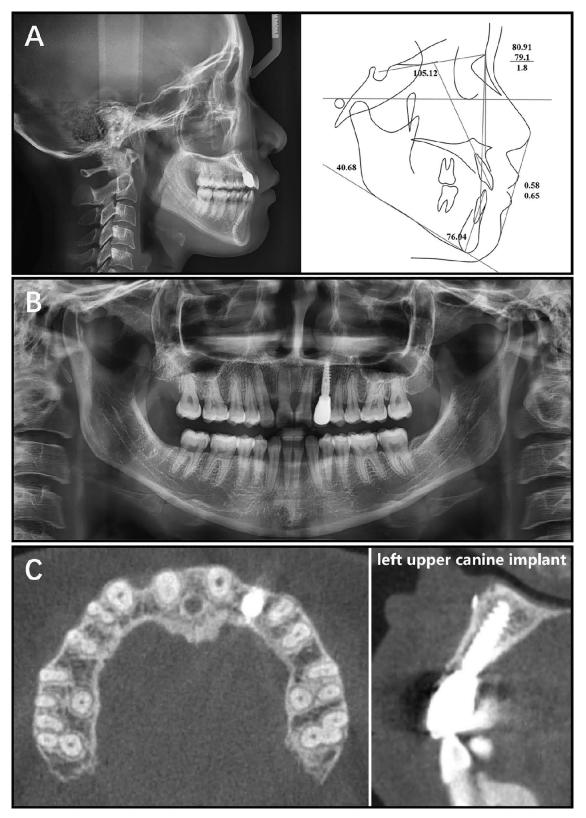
Posttreatment radiographs. (A) lateral cephalogram with tracing; (B) panoramic radiograph; (C) CBCT. CBCT indicates cone beam computed tomography.
